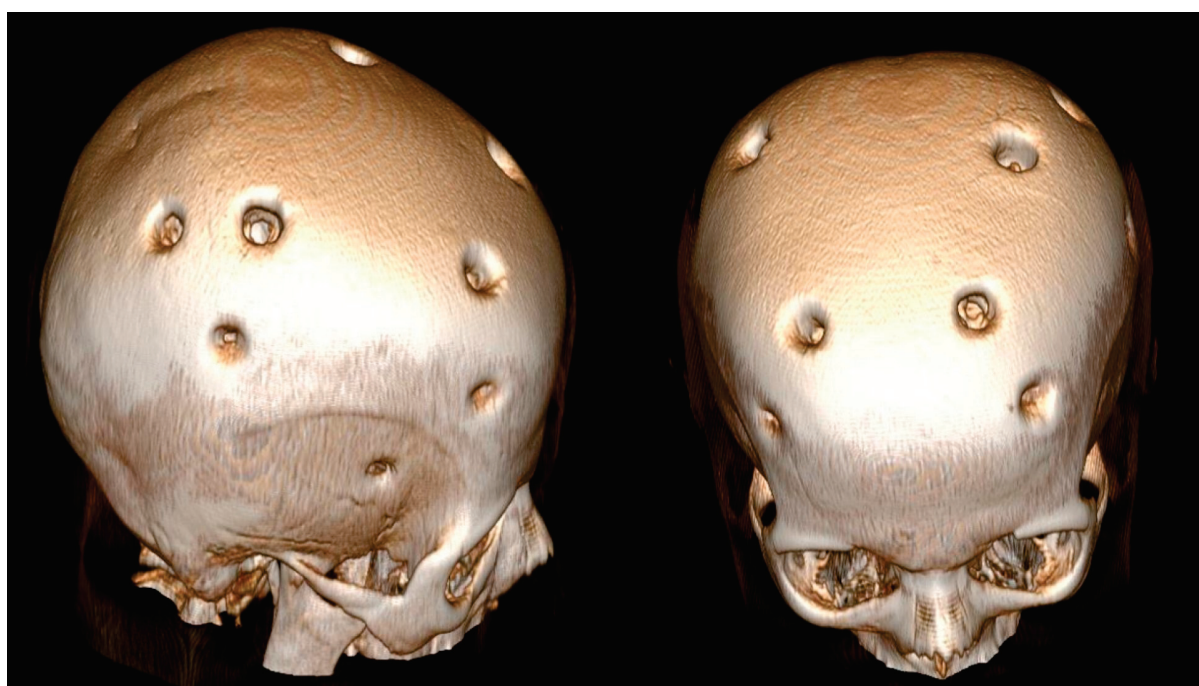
Three-dimensional brain CT reconstruction obtained 15 years after indirect revascularization, demonstrating the patient's appearance following the multiple burr hole (MBH) procedure.
